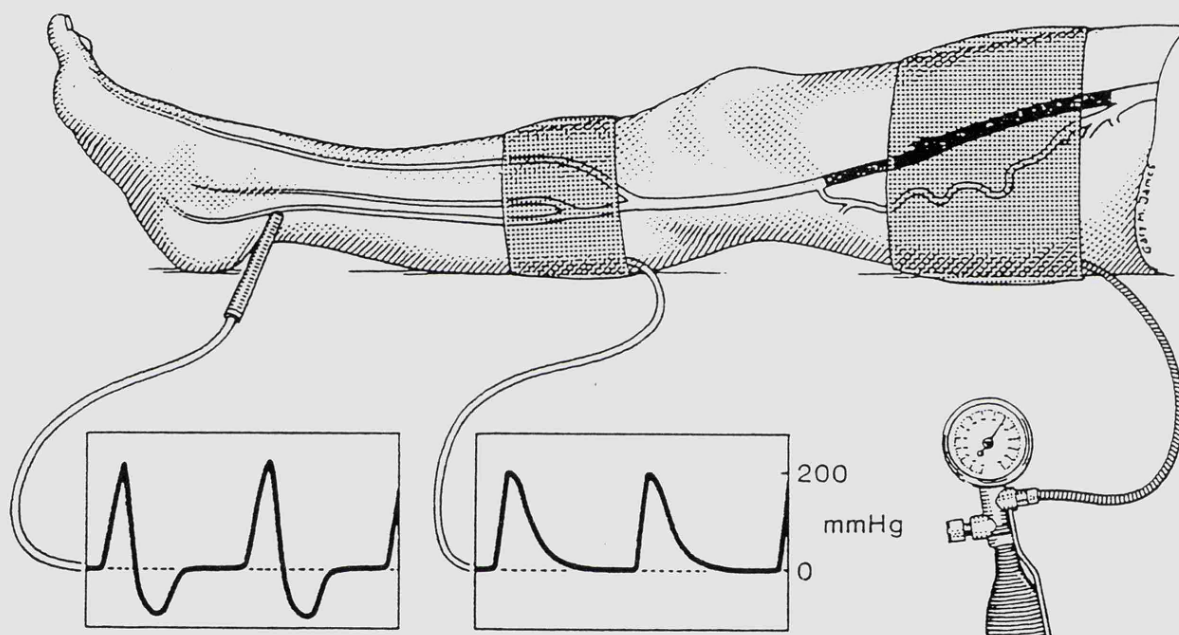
Pulsatile cuff at the upper calf with its corresponding pressure wave trace. The Doppler trace on the left shows the resultant augmented Doppler waveform at the ankle. The proximal thigh cuff is occasionally used in those patients with a patent superficial femoral artery, usually diabetics with distal disease.
